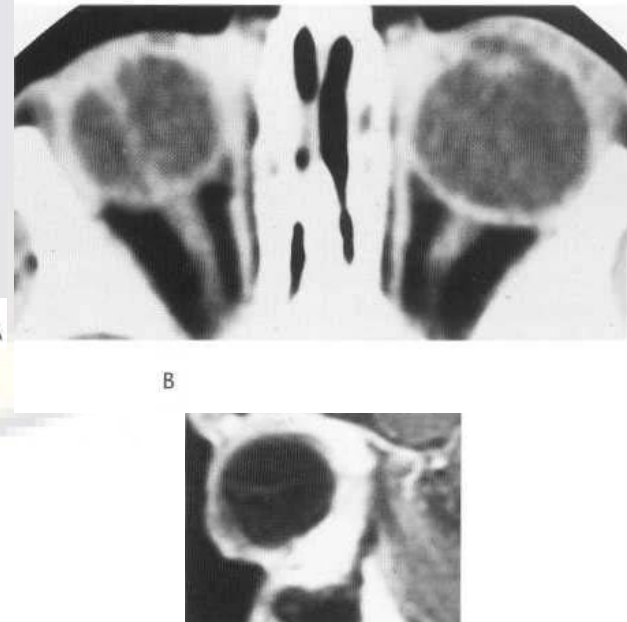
Persistent hyperplastic primary vitreous. Axial CT (A) demonstrates central linear density within smaller right globe. Sagittal T₁-weighted MR (B) confirms finding of PHPV.
